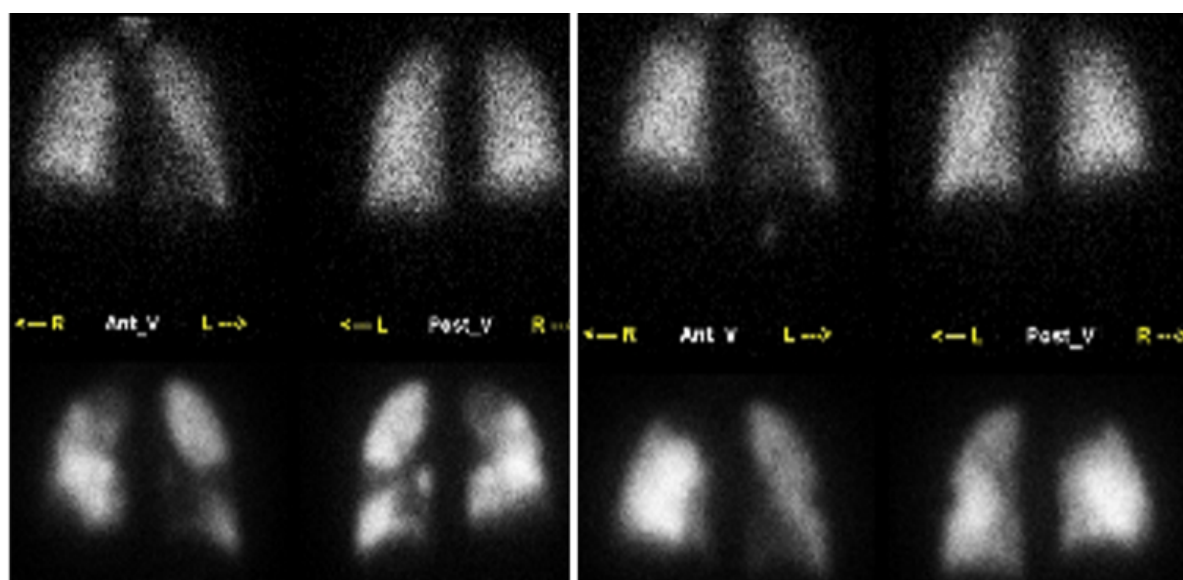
Planar images from a lung scintigraphy in pulmonary embolism.
